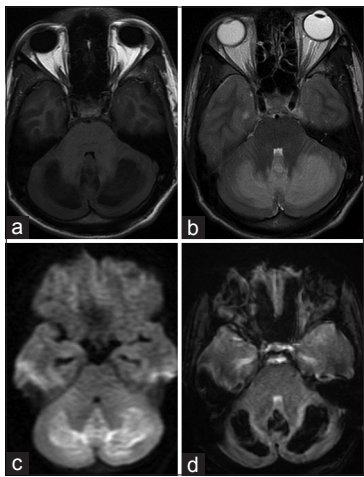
Axial magnetic resonance imaging T2-weighted, T1-weighted, and diffusion weighted images and gradient echo sequences (a-d) showing symmetrical hyperintensities in inferior cerebellum and vermis showing diffusion restriction, blooming
